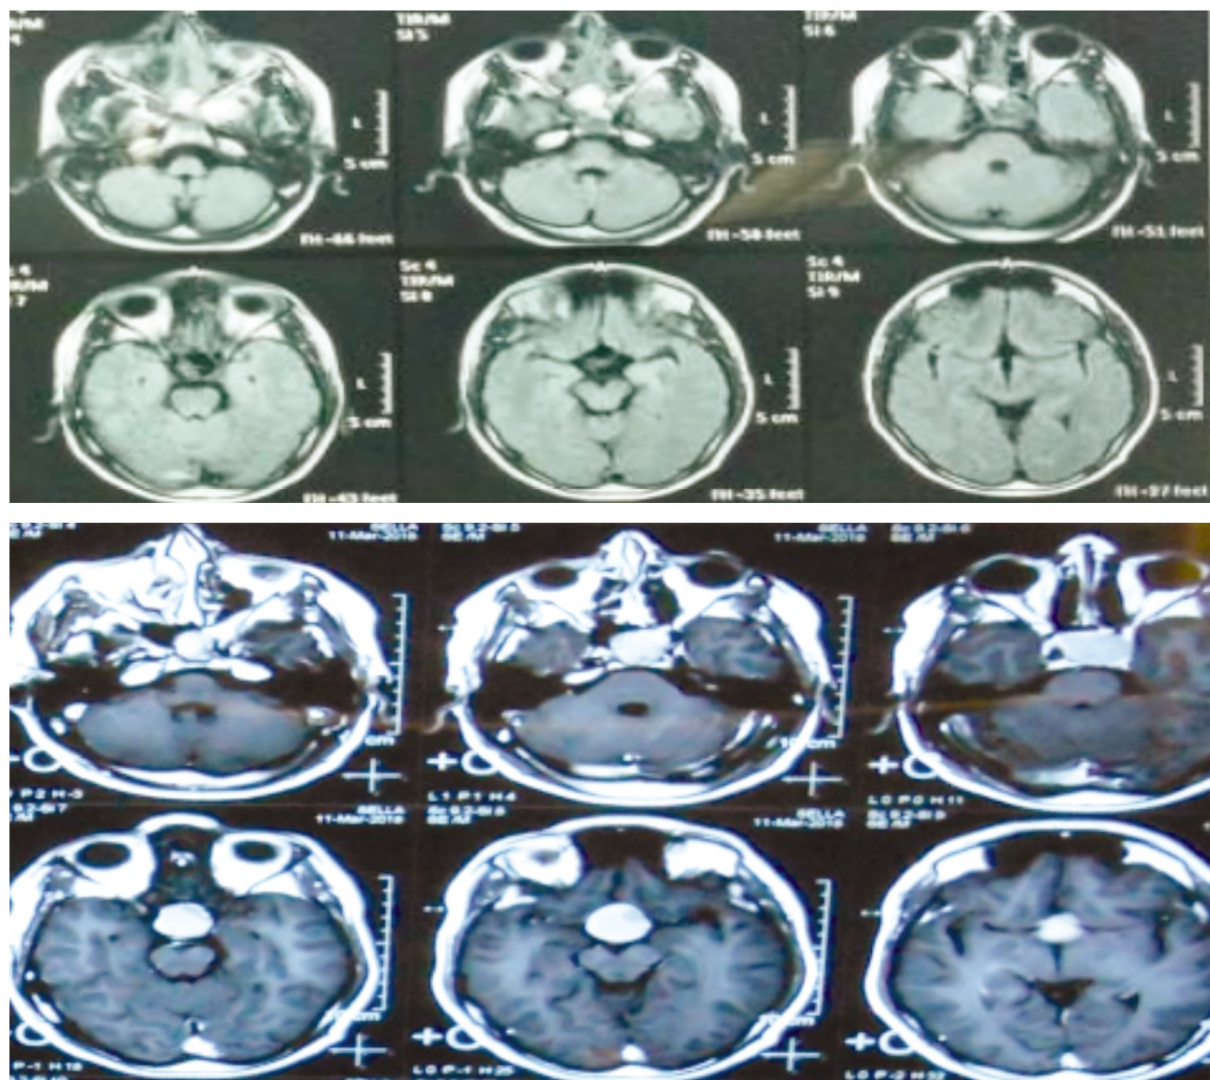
46 years old female with progressive course of diminution of vision and field affection for 5 months despite full medical treatment MRI sella with contrast showed large sellar and suprasellar mass, post-operative improvement was denoted by the post-operative CT.
